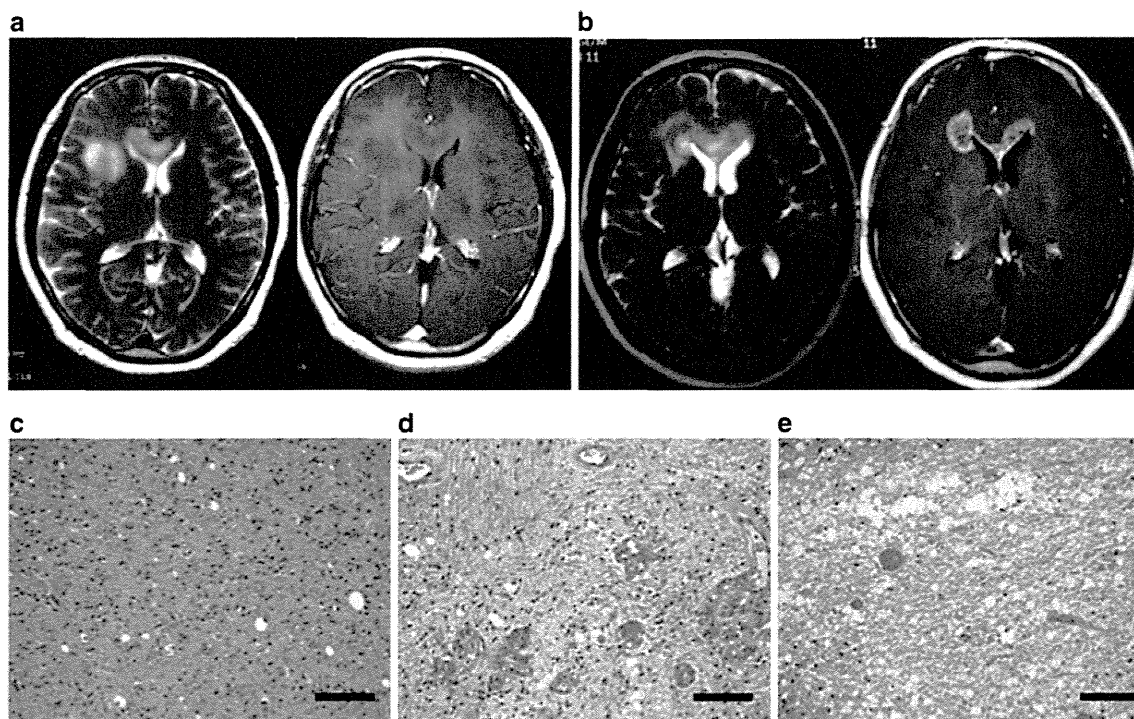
Representative case with malignant transformation in a 53-year-old woman with oligodendroglioma in the right frontal lobe and corpus callosum. T2-weighted (*left*) and T1-weighted with gadolinium (*right*) magnetic resonance (MR) images at first presentation (a), demonstrating that the tumor had an ill-defined tumor border extending to the corpus callosum without enhancement. Primary tumor obtained from open biopsy consisted of round cells with a perinuclear halo but without microvascular proliferation or necrosis, and the diagnosis was oligodendroglioma (c). Analysis of IDH1 mutation revealed that the tumor had
